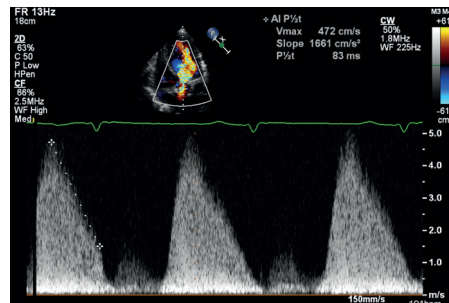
Aortic regurgitation as seen on apical 5-chamber view on echocardiogram in colour Doppler mode.
